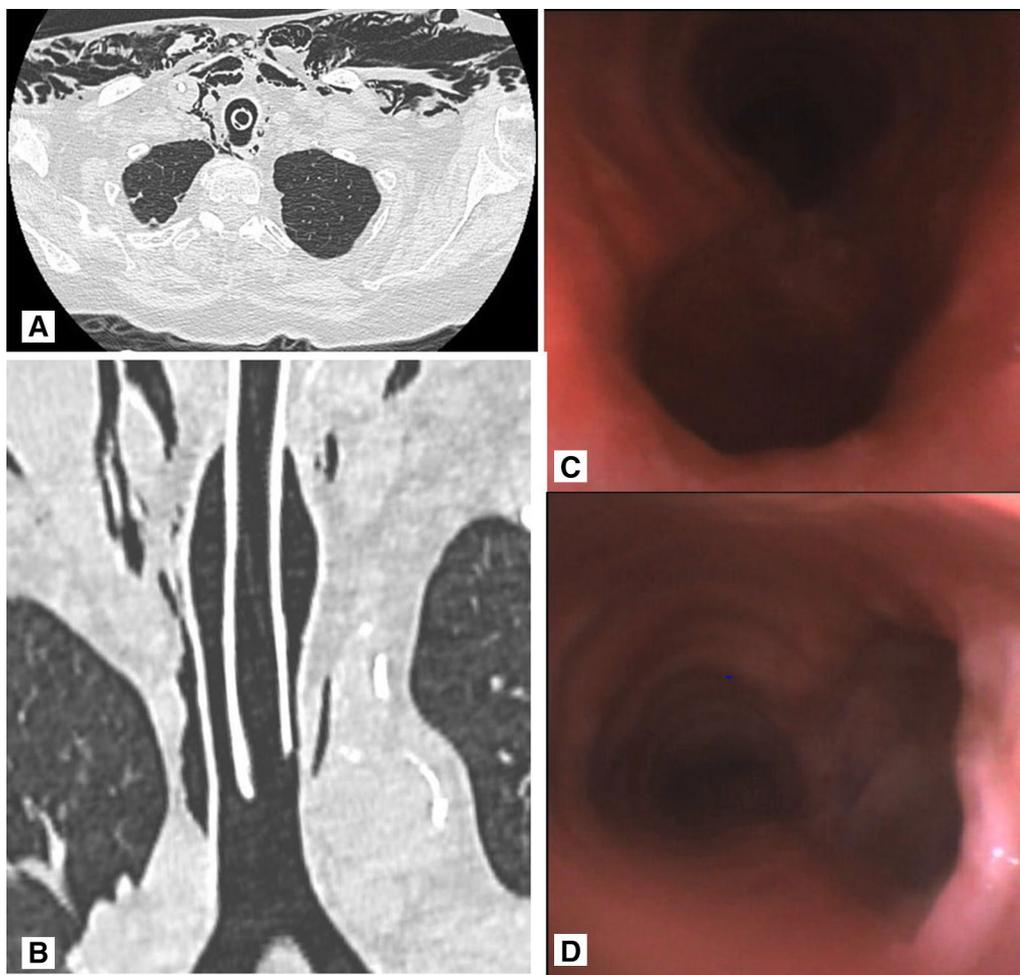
Computed tomography (MDCT). a Axial images of the chest showing airfilled tracheal diverticulum located at the right posterior paratracheal area adjacent to the esophageal lumen in the mediastinal window. b coronal images of the chest showing a lobulated multiseptated air-filled tracheal diverticulum located at the paratracheal area in the parankim window. c First bronchoscopy, performed after intubation, that shows an area of laxity of the pars membranacea. d Second bronchoscopy, performed 1 week later, that confirms the presence of a tracheal acquired diverticulum while excluding a tracheo-oesophageal fistula
